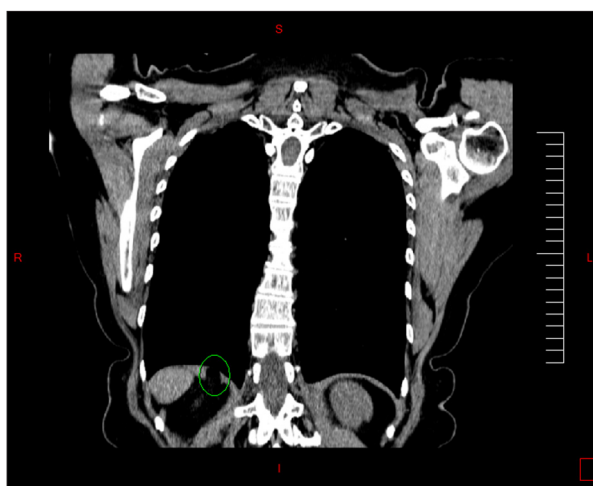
CT scan axial section showing diaphragmatic lipoma marked with a green circle.
